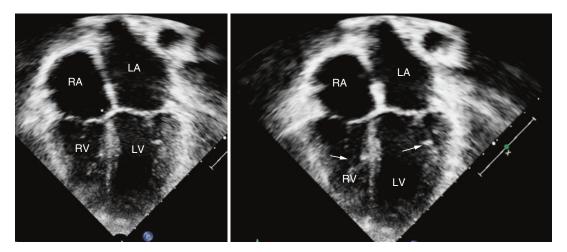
Apical four chamber view demonstrating normal offset of the mitral and tricuspid valves. (a) Note that the MV is inserted further from the cardiac apex than the TV; the differential insertion is marked with an asterisk (*). (b) Note the attachments of the MV and TV. The attachments of the MV are to the free wall of the LV
